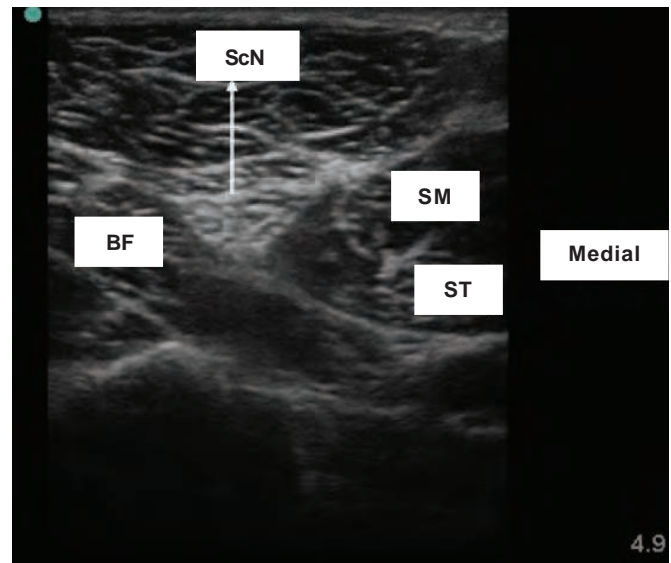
A high-frequency linear ultrasound transducer is placed transversely, above the popliteal crease. The sciatic nerve is usually located posterolateral to the vessels and is seen between biceps femoris muscle and semimembranosus and semitendinosus muscles
